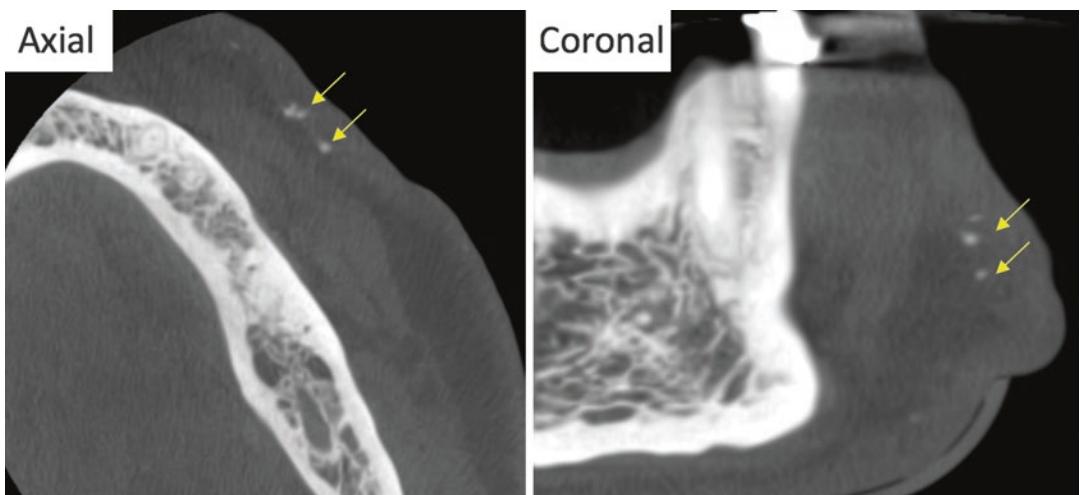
Extradermal calcifications are shown on the CBCT images (yellow arrows). Axial, coronal and sagittal images show multiple smaller rounded calcifications on the buccal aspect of the mandible within the soft tissue
